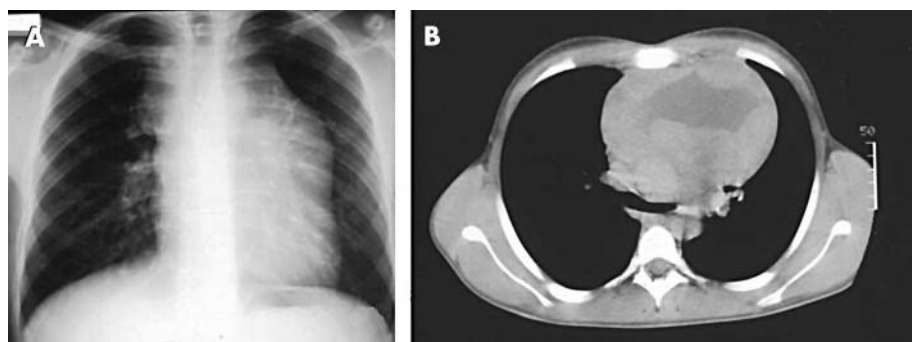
(A) An x ray shows an enlargement of the mediastinum involving particularly the left side of the chest. (B) A chest computed tomography scan shows a voluminous mass with well defined edges and non-homogeneous density, involving predominantly the left part of mediastinum.
